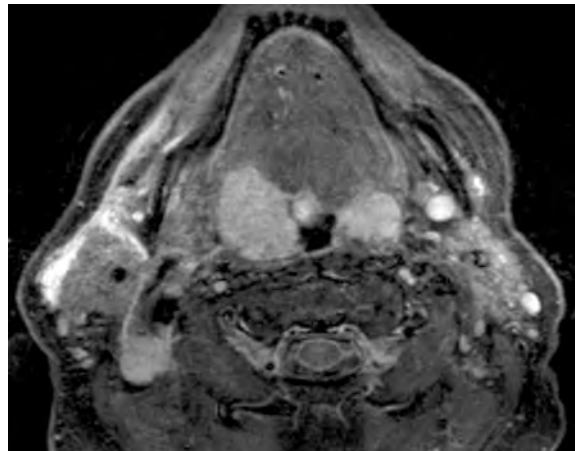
Tonsillar NHL. Axial T2-weighted sequence (TIRM) demonstrates bilateral high signal intensity (SI) soft-tissue masses in the tonsil. *Note* that there is no invasion of the surrounding deep-tissue planes. There is an associated enlarged level II lymph node on the right with the same high SI appearance
